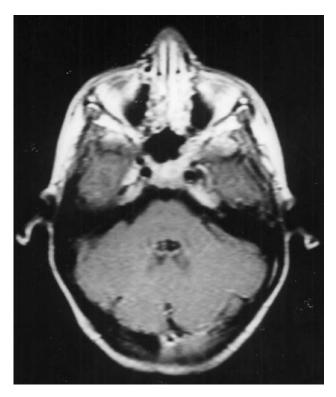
Axial T1-weighted brain MR image in a child with NF2 showing no intracranial lesion [reprinted with permission from Ruggieri et al. 2005].
